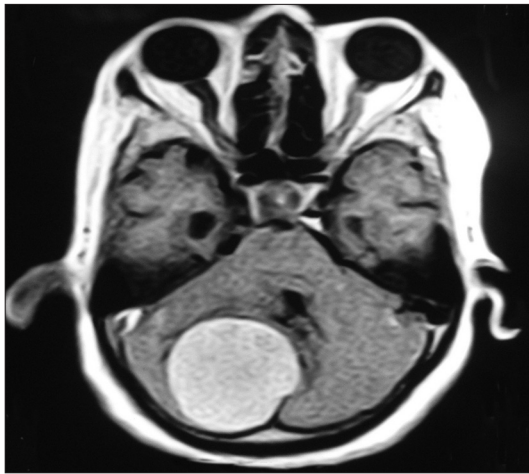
Preoperative MRI image. Axial T1-weighted contrast image shows a huge homogeneously enhancing mass in the right cerebellar hemisphere. The left facial-vestibular nerve complex is kinked and stretched over the internal acoustic meatus
